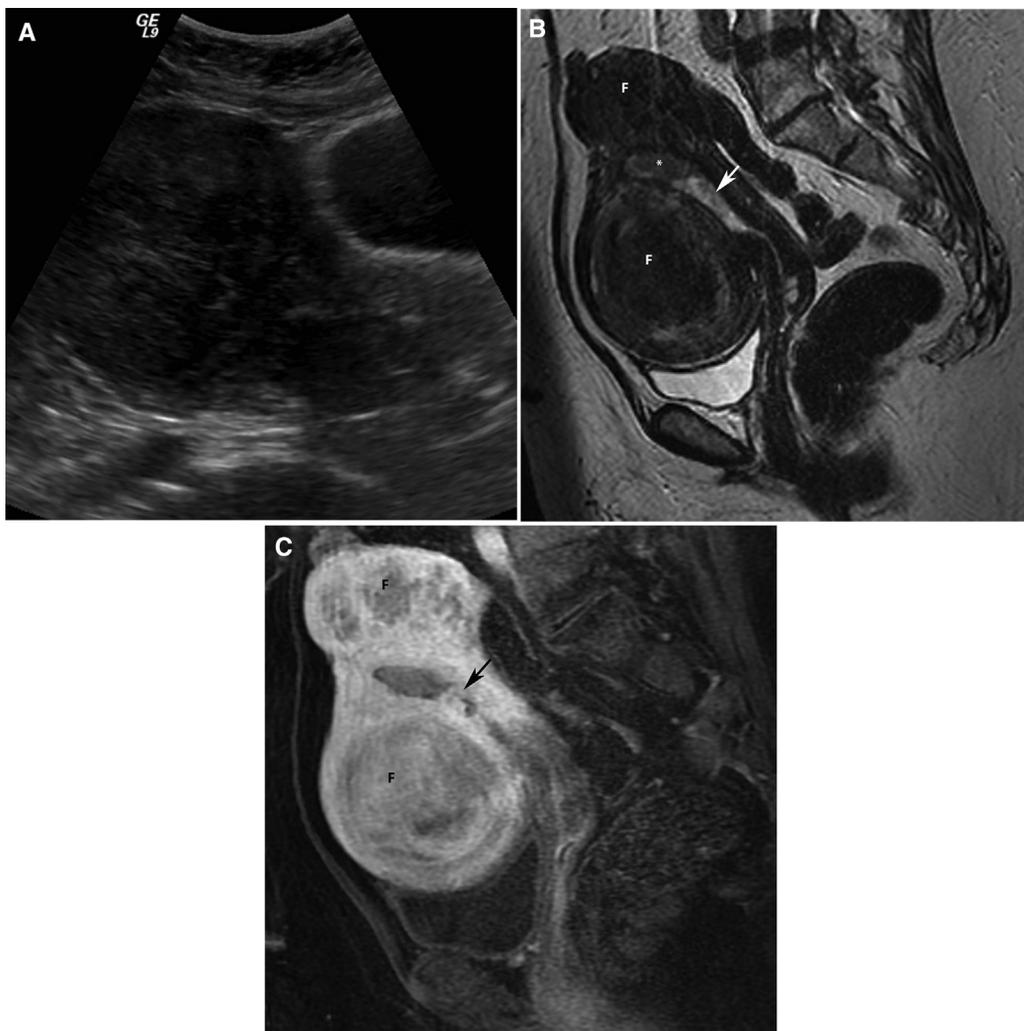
A 57-year-old woman with postmenopausal bleeding. (A) Transvaginal sagittal ultrasound shows enlargement of the uterus due to multiple fibroids. The endometrium cannot be evaluated. (B) Sagittal T2 magnetic resonance imaging (MRI) demonstrates thickening of the endometrium with heterogeneous areas of low T2 signal intensity (asterisk; white arrow) that represent abnormal endometrial tissue. (C) Sagittal gadolinium enhanced fat suppressed T1 MRI demonstrates enhancement of the abnormal endometrial tissue (black arrow). There is no myometrial invasion. Endometrial biopsy revealed endometrioid adenocarcinoma. In addition there are typical exophytic subserosal fibroids that are low signal intensity on T2 and enhance with contrast (F).
